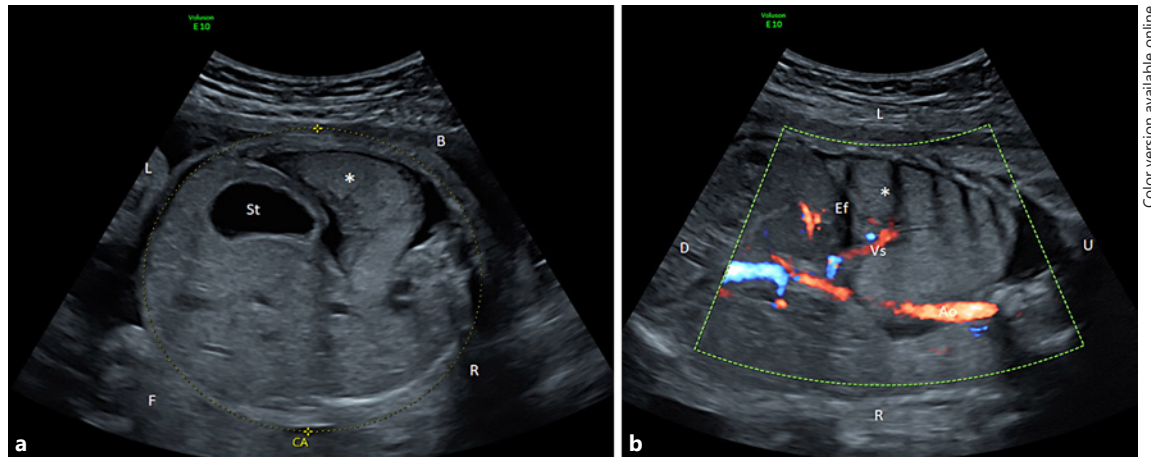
a Preoperative ultrasound exam. b Axial view: left isoechoic BPS (*) surrounded by pleural Ef. Preoperative ultrasonography exam, frontal view, Doppler: visualization of the feeding vessel (Vs) of systemic origin vascularizing BPS (*) which is a posterior left basal triangular isoechoic image, surrounded by pleural Ef. U, up; D, down; Ef, effusion; St, stomach; R, right; L, left; BPS, bronchopulmonary sequestration.
